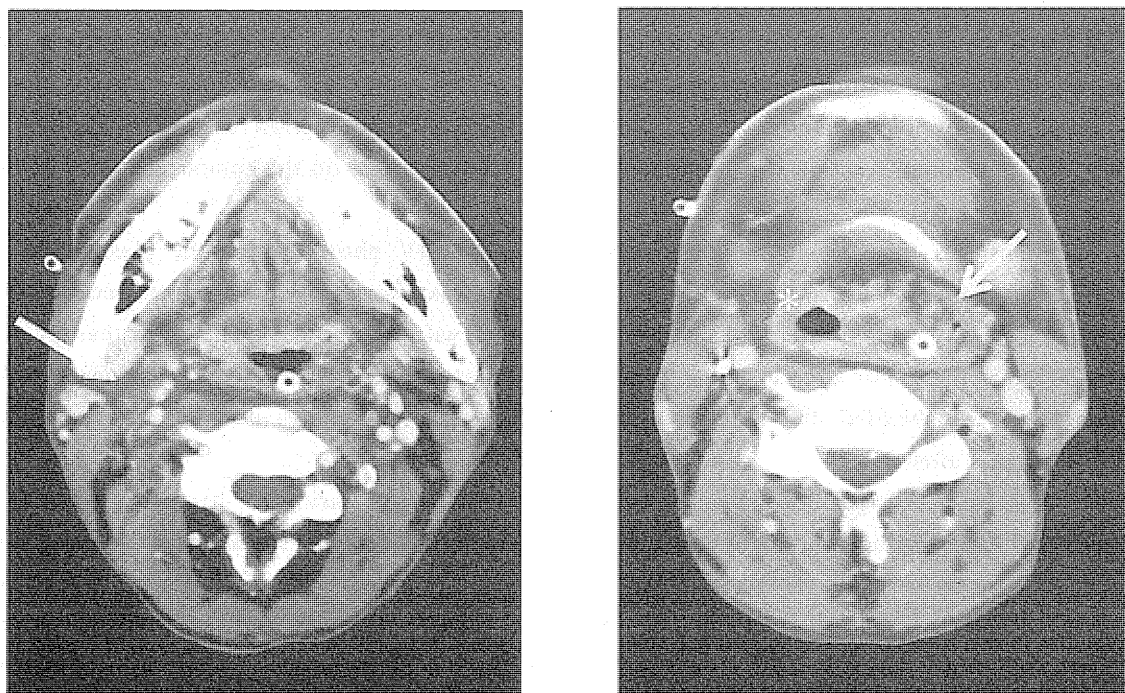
X-ray CT scan two months after the end of thermoradiotherapy. Cervical metastatic nodes were shrunk and markedly decreased enhancement effect (4a →). However laryngeal edema was occurred and regrowth of the local tumor was suspected (4b).
